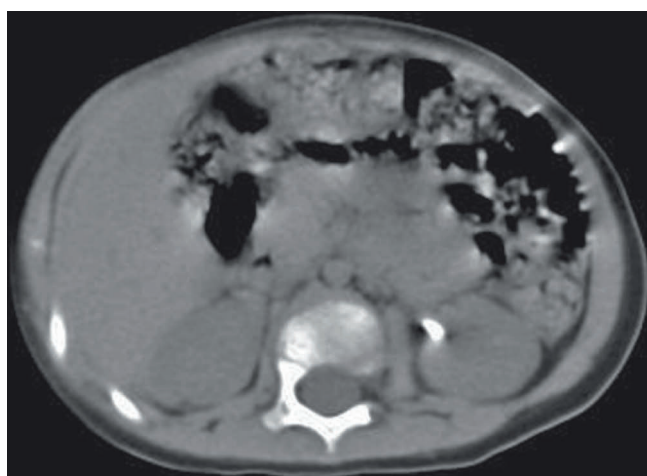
CT scan of a patient with a melamine stone
